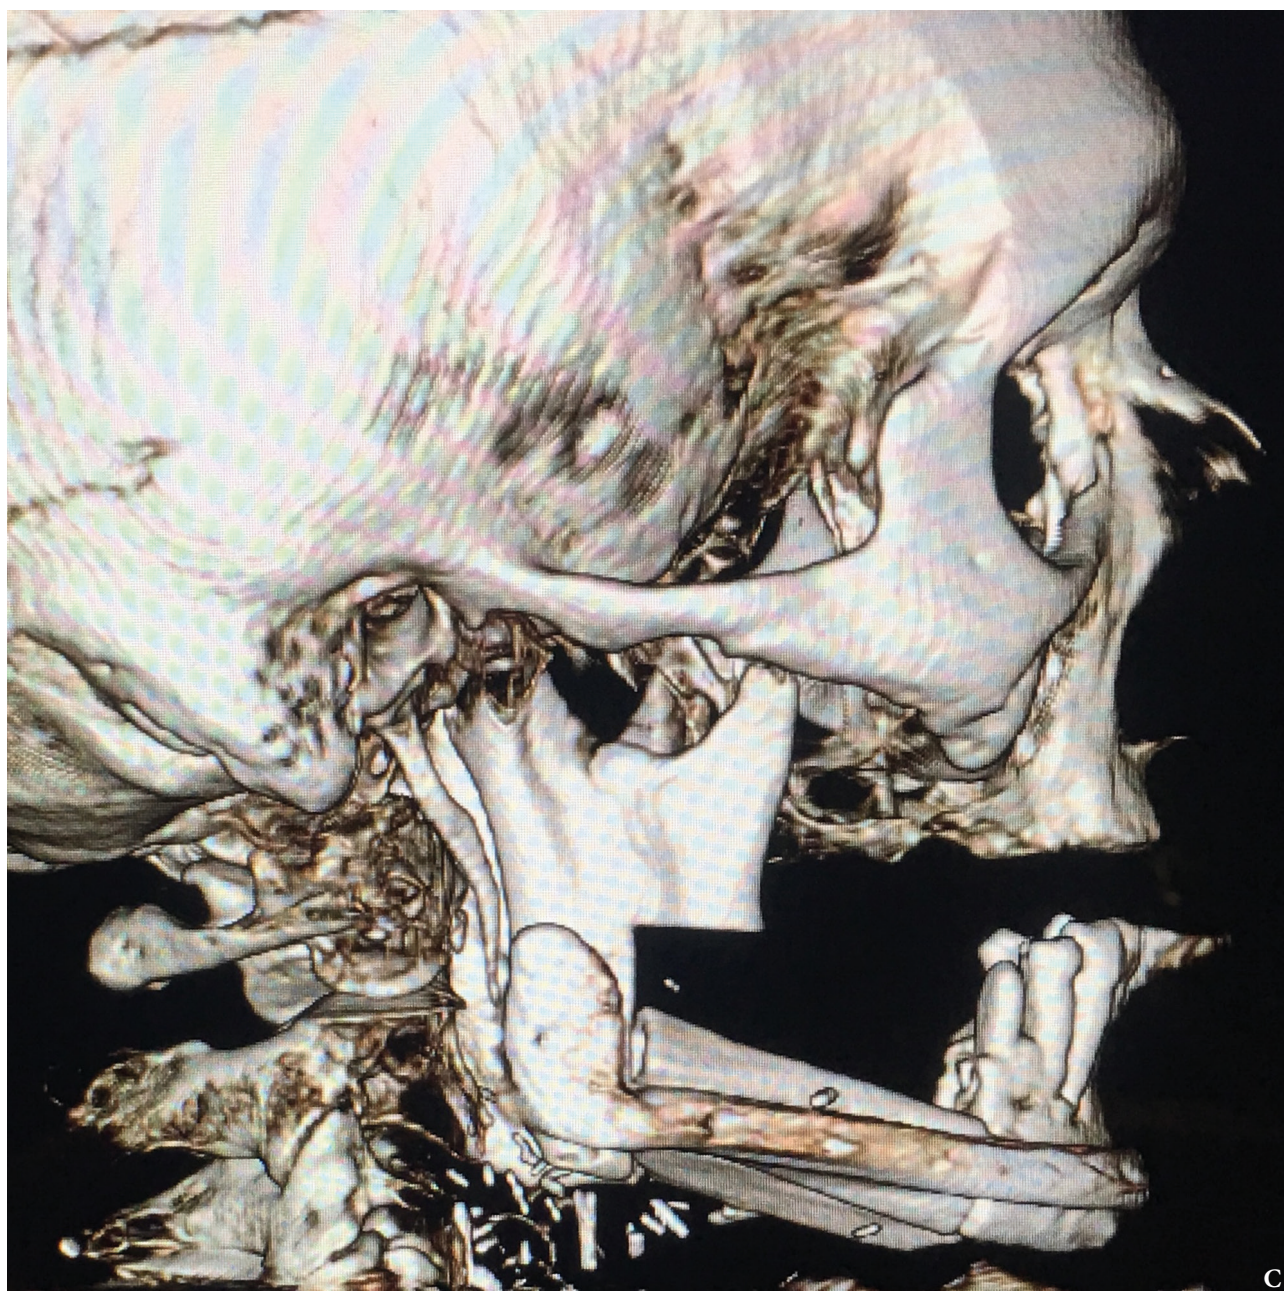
(cont'd). Postoperative control of reconstruction with 3D-CT: Right lateral view (C). (Fig 7 continued on next page.)
